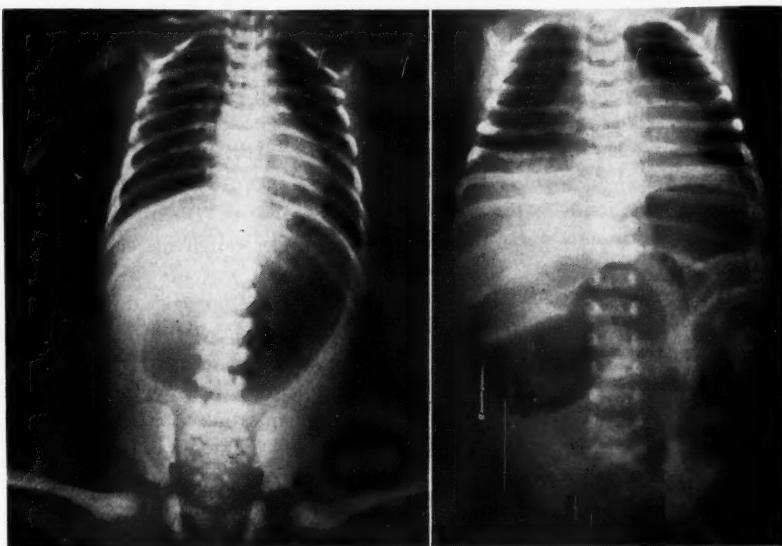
Plain roentgenogram from a newborn infant with atresia of the duodenum. The gas shadows are limited to the stomach and the first portion of the duodenum.
